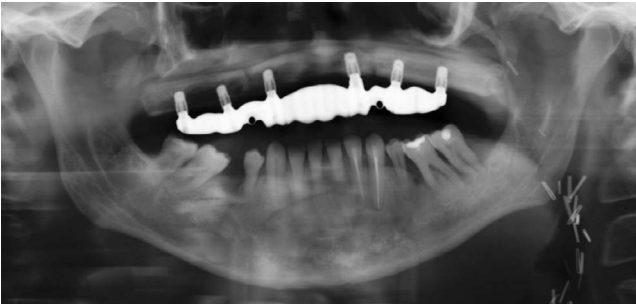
The panoramic radiograph with a bar connected to the implants.
